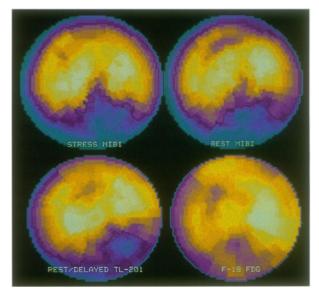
Viable hibernating myocardium. Stress and rest Tc-99m sestamibi polar plots (top row) demonstrate a moderate, fixed inferior defect. A subsequent Tl-201 SPECT study (lower left), performed 4 hours after a resting injection of 3.5 mCi Tl-201, demonstrates only slight reversibility of the inferior defect. However, a resting F-18 FDG SPECT study (lower right), performed on a dual-headed scintillation camera equipped with ultra-high energy collimators, demonstrates complete reversibility of the inferior defect, indicating viability.
